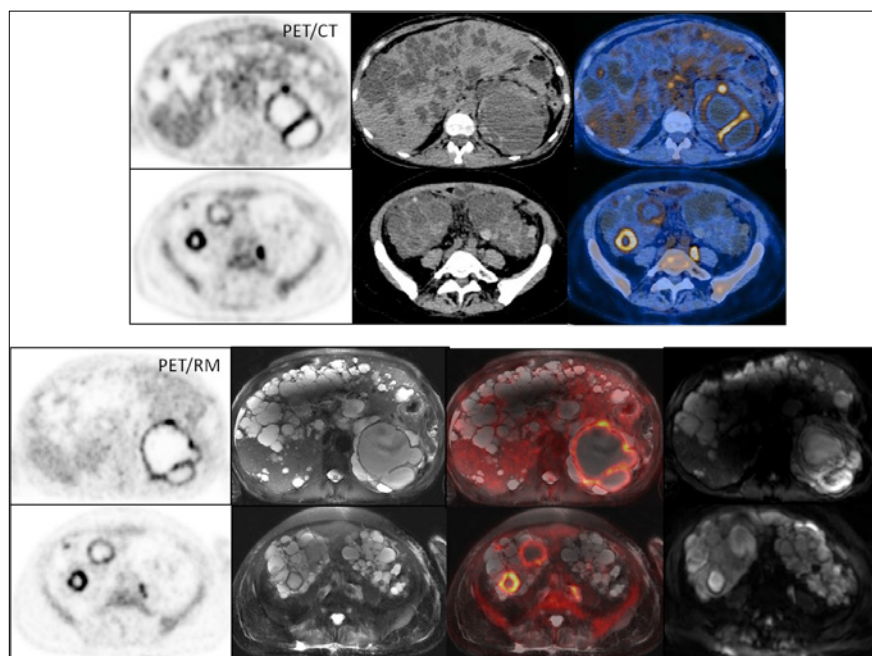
PET/CT (top) and PET/MRI (bottom) showing axial slices with T2-weighted sequences and diffusion. A female patient with polycystic kidneys and pain on palpation of the left flank, undergoing investigation due to fever of unknown origin. The PET/CT and PET/MRI studies showed an increase in glycolytic metabolism and diffusion restriction in multiple bilateral renal cysts, suggestive of an active inflammatory/infectious processes. The case demonstrates the possibility of correlating the molecular information of the PET (glycolytic metabolism of the inflammatory process) with data from functional MRI sequences, namely diffusion (increased cellularity also related to the inflammatory process), increasing the diagnostic conspicuity.
